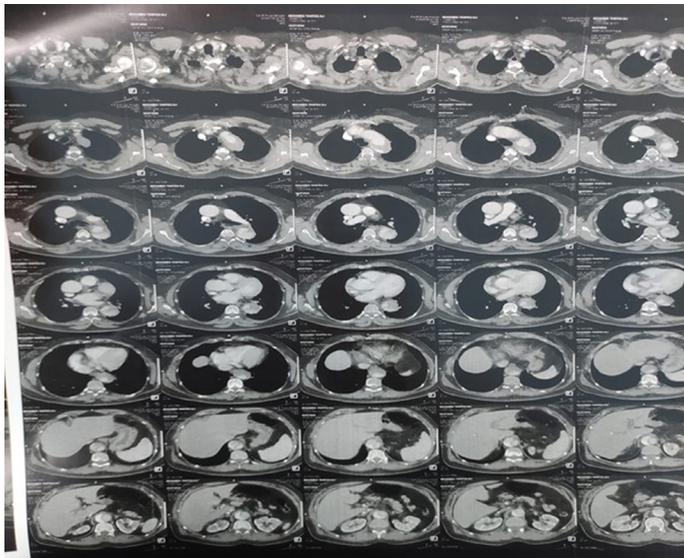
CT Aortography of Type B Aortic dissection
